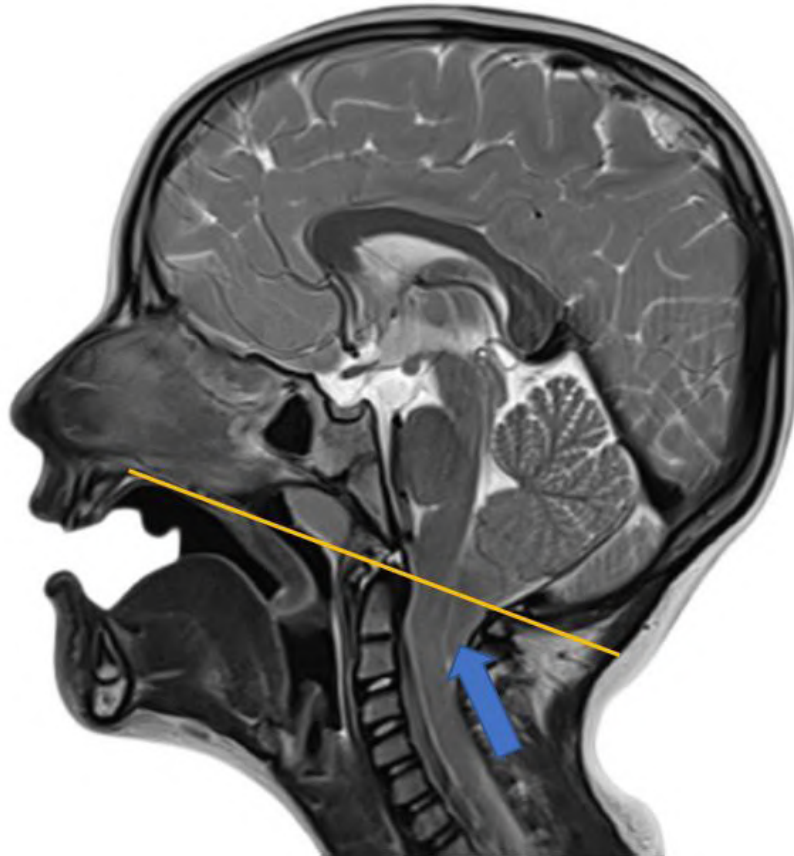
MRI showing displacement of the cerebellar tonsils (blue arrow) below Chamberlain's line (orange line) bilaterally.
